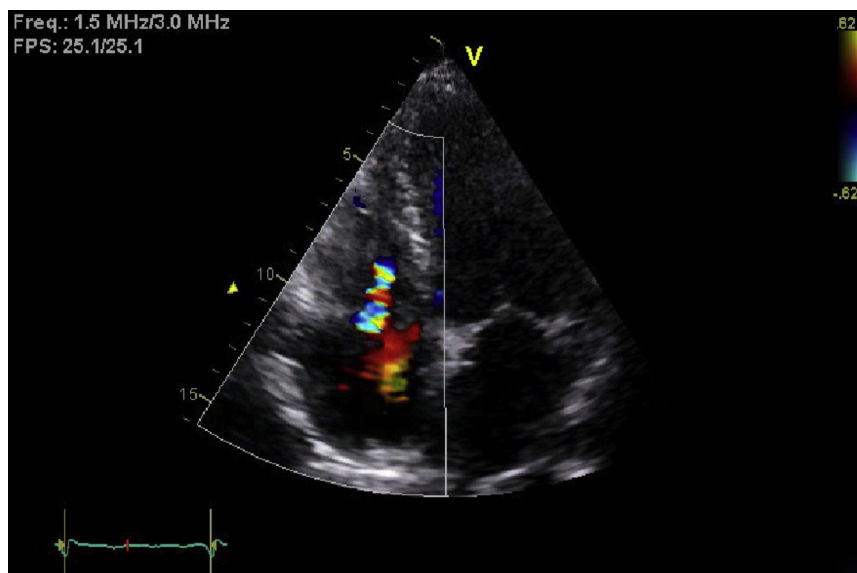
Transthoracic echocardiogram after lead extraction and prior to LP insertion showing mild to moderate TR in an apical four-chamber view.
